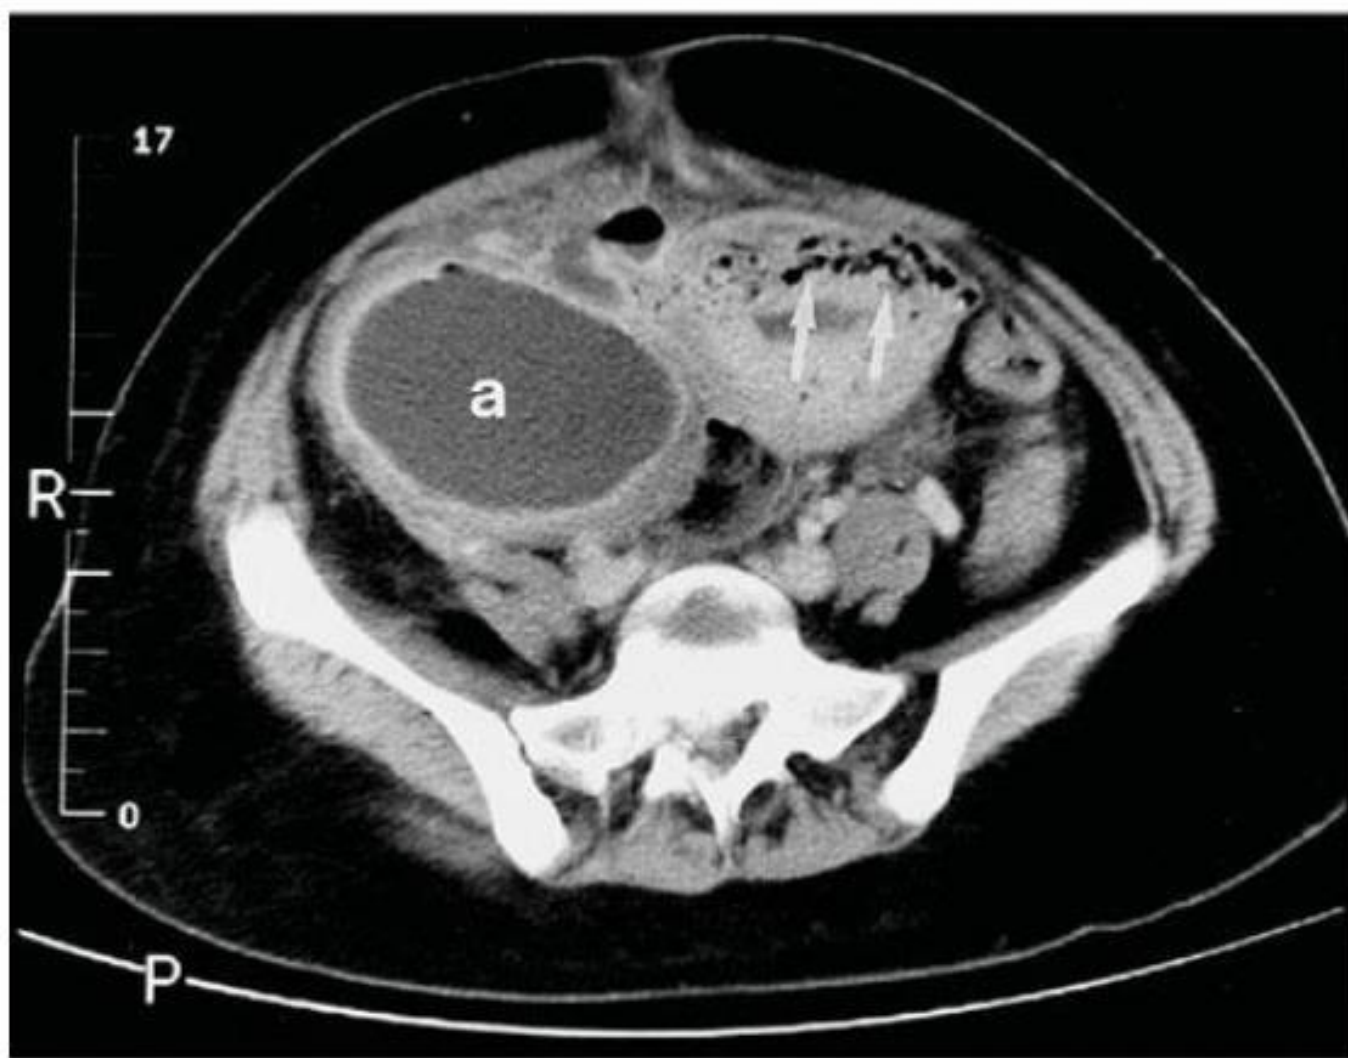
Pelvic computed tomography scan showing necrosis of the uterine incision with gas in the myometrium (*arrows*). There is also a large right-sided parametrial abscess (*a*).
